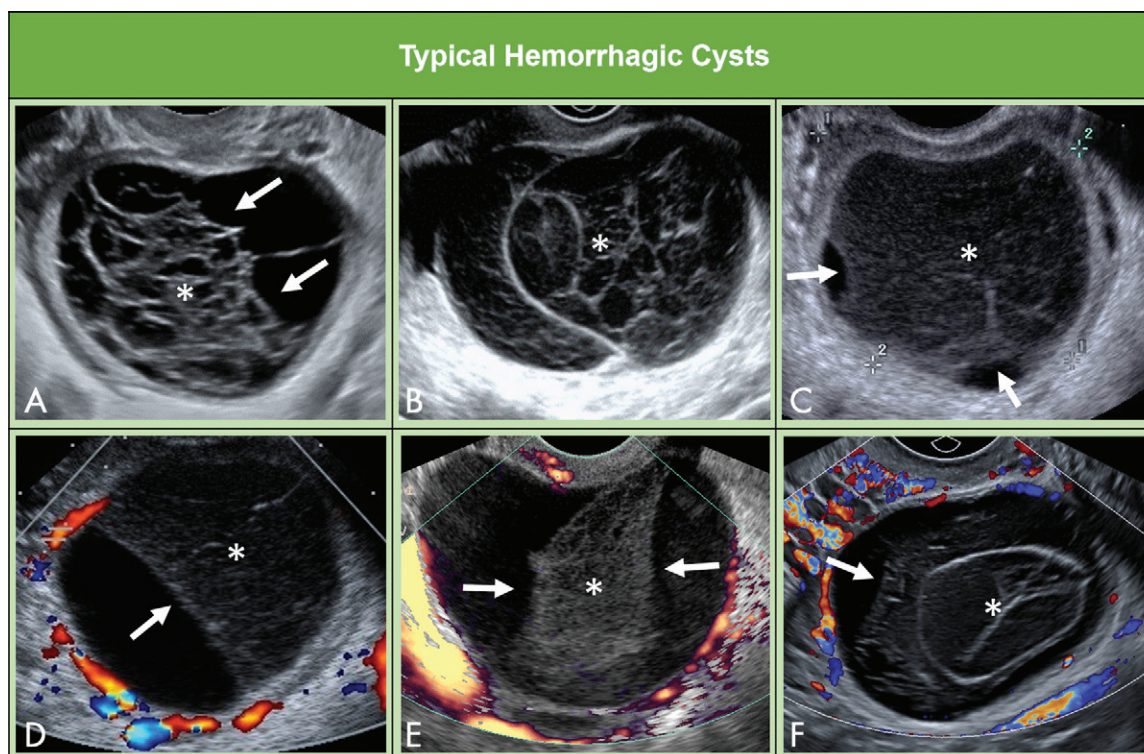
Images show typical hemorrhagic cysts. A, Ovarian hemorrhagic cyst with retracting clot demonstrates concave margins (arrows) and internal reticular pattern (asterisk). B, Hemorrhagic cyst with reticular pattern (asterisk) throughout. C, Reticular pattern (asterisk) with fine discontinuous linear echoes and early retraction of clot at periphery (arrows). D, Retracting clot with reticular pattern (asterisk) and concave margin (arrow). Color Doppler flow is seen in surrounding ovarian tissue; however, it is absent within blood products. E, Reticular pattern (asterisk), straight and concave margins (arrows), and no flow at color Doppler energy differentiates retractile clot from solid tissue. F, Avascular hemorrhagic cyst with reticular pattern (asterisk) and concave margin of retractile clot (arrow).
